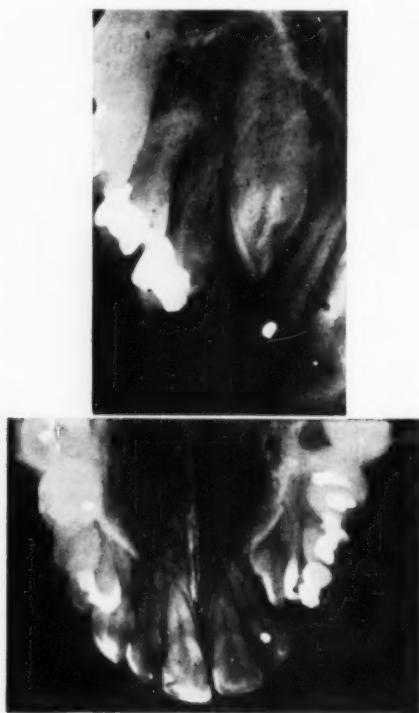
Radiograph taken vertically downwards reveals the true position of the unerupted cuspid.
